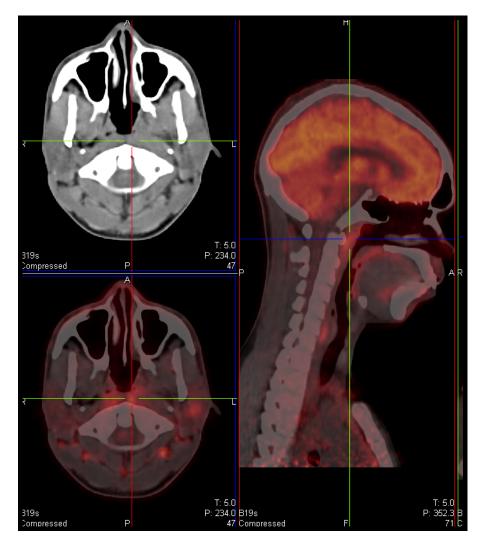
PET-CT of the nasopharynx.
